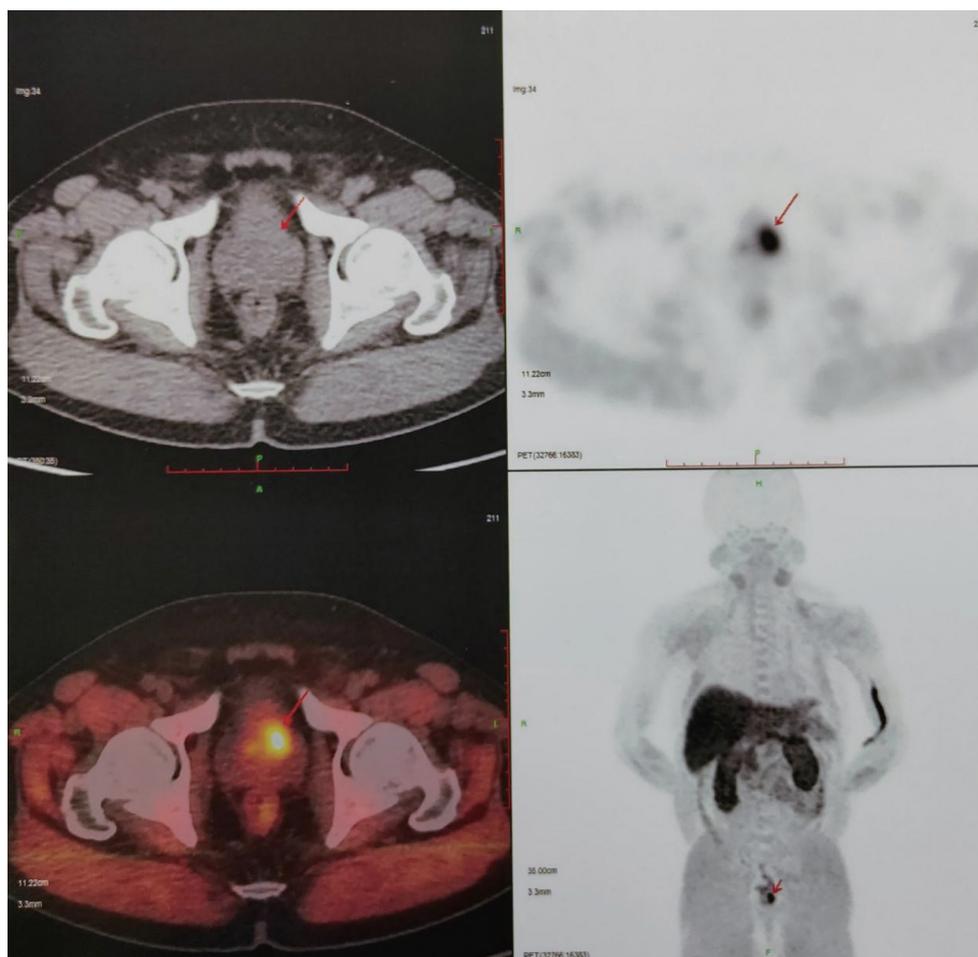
^{68}Ga PSMA-11 PET/CT in the pituitary dwarfism. Red arrow indicates a prostate mass.
